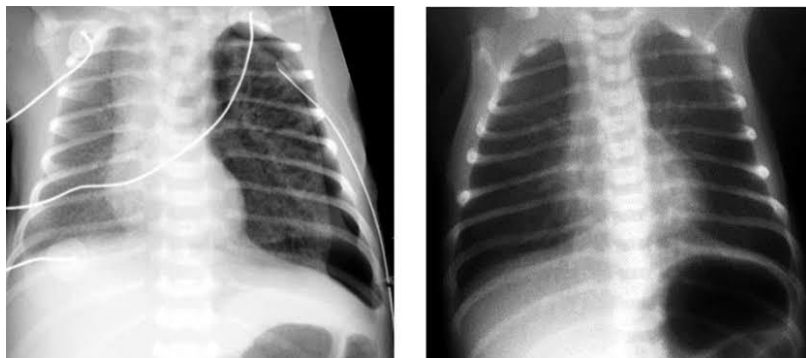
Images of chest xray in neonate with RDS before surfactant(left side)and after surfactant(right side)
